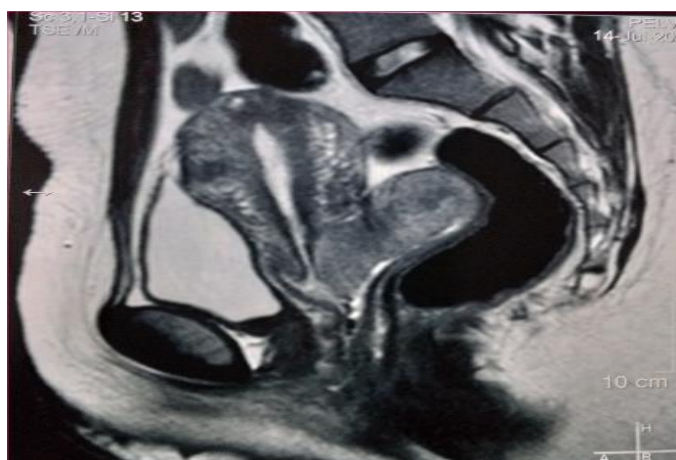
MRI appearance of the lesion
